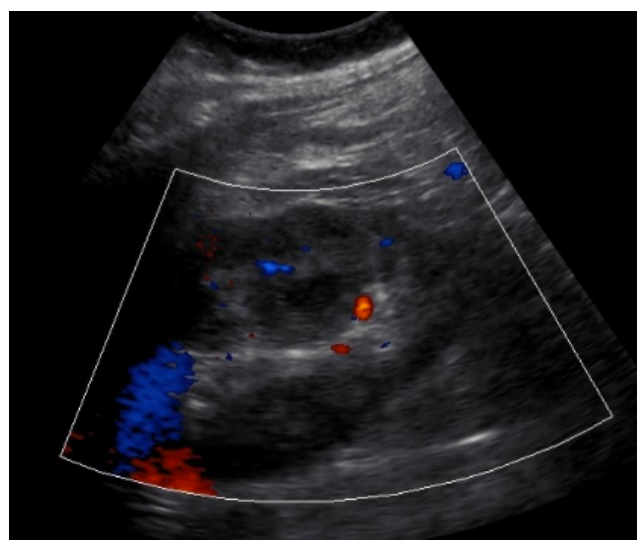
Ultrasound of the left retroperitoneum showing a 2 cm echogenic focus in the left kidney, calculi versus gas.
